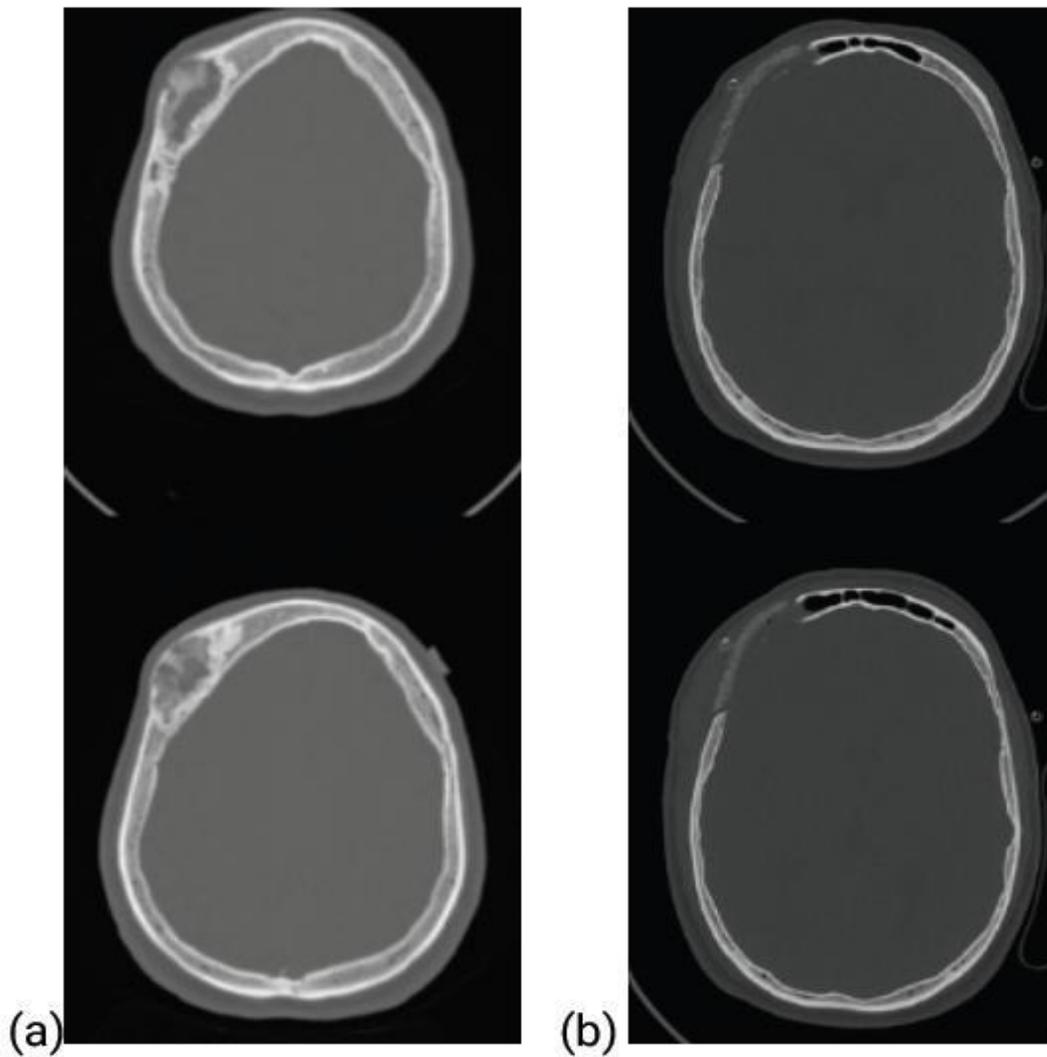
Fibrous Dysplasia. (a) axial head CT images demonstrate an expansile osteolytic lesion with the typical ground-glass matrix in the right frontal bone. (b) postoperative axial head CT images bone window after 3D reconstruction of the skull.
